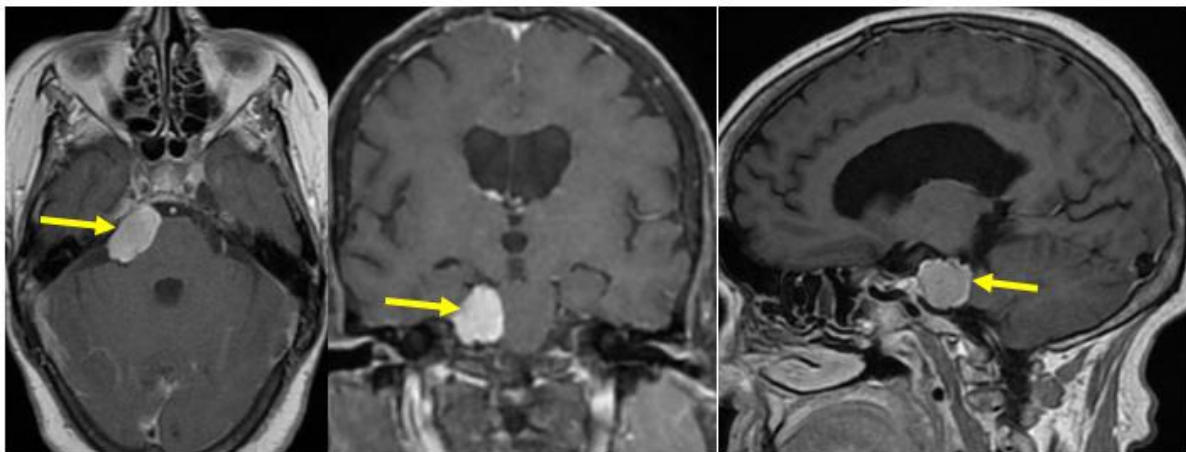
Three-dimensional post-contrast brain MRI sequence depicting early and homogeneous enhancement of the lesion (yellow arrow) following Gadolinium administration
